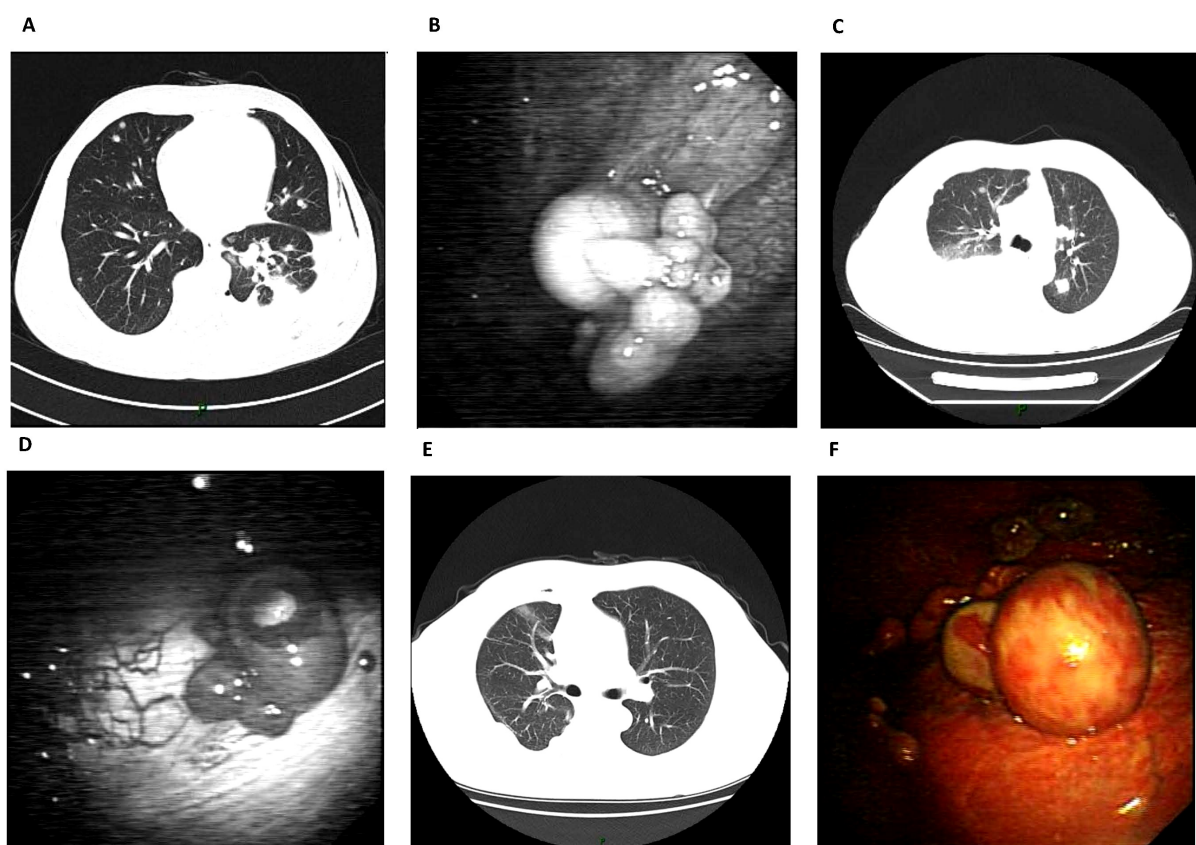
A) Chest CT: pleural effusion and bilateral multiple pulmonary nodules. B) Medical thoracoscopy: multiple nodules in the parietal wall, presenting cauliflower-like lesions. C) Chest CT: pleural effusion and bilateral multiple pulmonary nodules. D) Medical thoracoscopy: multiple nodules in the parietal wall, rich in blood supply. E) Chest CT: nodules in the right pleura and pleural effusion. F) Medical thoracoscopy: multiple nodules in the parietal wall, rich in blood supply.
